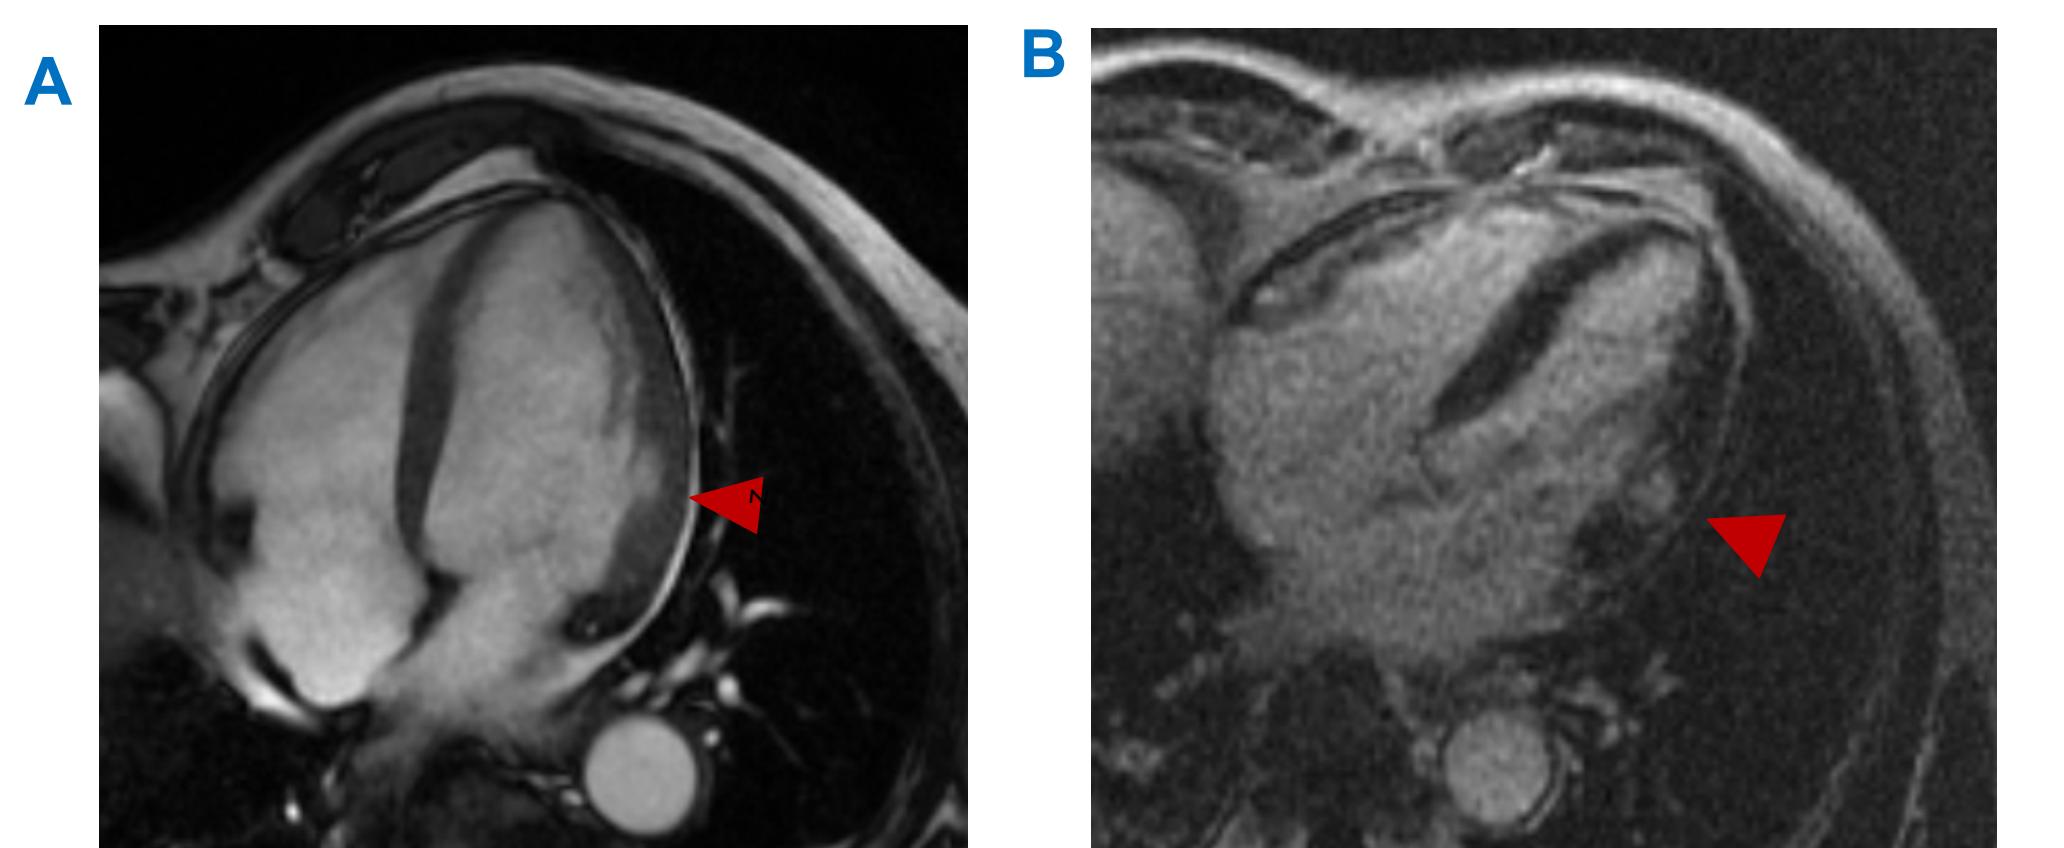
Representative cardiac magnetic resonance images. A) Cine four-chamber view showed focal thinning/hypokinesis with abnormal delayed myocardial enhancement (>50% myocardium) in the basal-lateral wall with a small pericardial effusion, B) four-chamber delayed-enhancement MRI showed abnormal enhancement in basal-lateral wall, C) T2-weighted short axis view showed subtle hyperintensity consistent with myocardial edema in the anterolateral wall. Follow-up cardiac MRI one month later showed persistent LGE in basal-lateral wall and resolution of myocardial edema and pericardial effusion.
